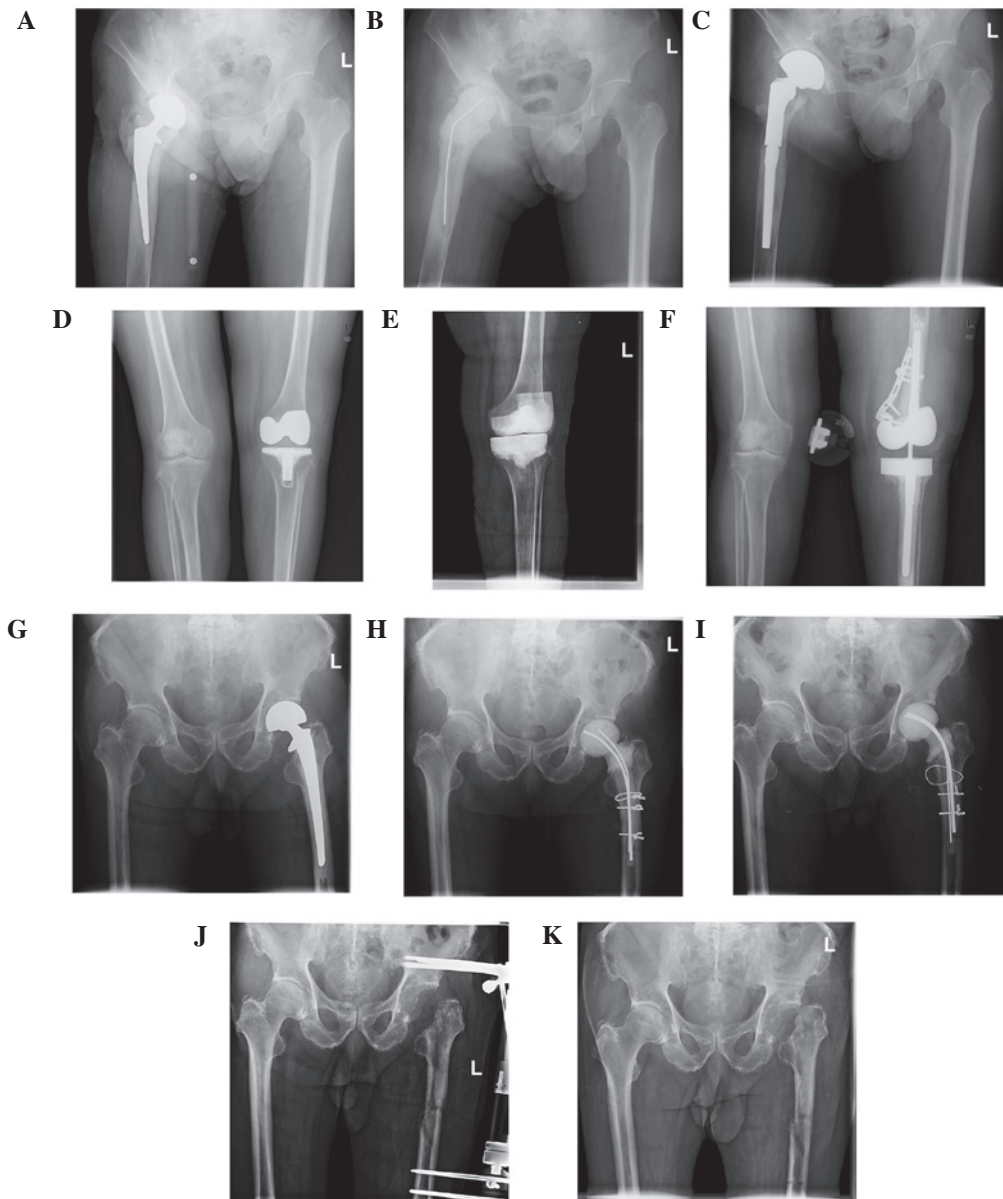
Preoperative and postoperative X-rays of three cases of a fungal PJI. The X-ray images present the two-stage exchange protocol method for knee and hip joints and the method of resection arthroplasty. (A) Case 1 suffered from fungal PJI of the hip; (B) the prosthesis was removed and the cement joint spacer was implanted. (C) Following treatment with antifungal agents in the interim period, the cement spacer was removed and the prosthesis was reimplanted. (D-F) Case 6 underwent a similar therapeutic program, although the patient suffered from fungal PJI of the knee. (G-I) Case 4 was treated with the cement spacer, but then refused to receive reimplantation of the prosthesis; therefore, (J and K) resection arthroplasty was performed. PJI, prosthetic joint infection.
